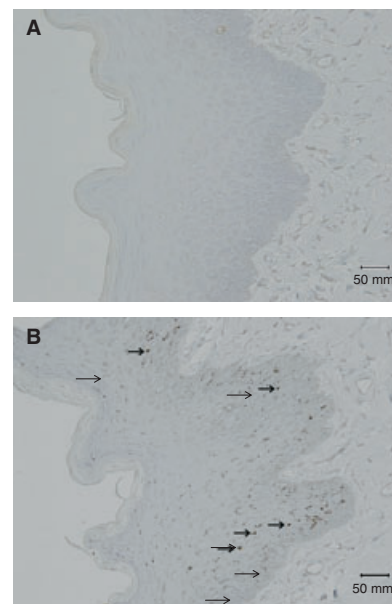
Expression of heat shock protein 70 in gingival tissues of the control group (A) and of the low-intensity pulsed ultrasound-treated group (B). Bars represent 50 μ m at the original magnification of $\times 40$. Arrows indicate areas where a positive reaction occurred.
